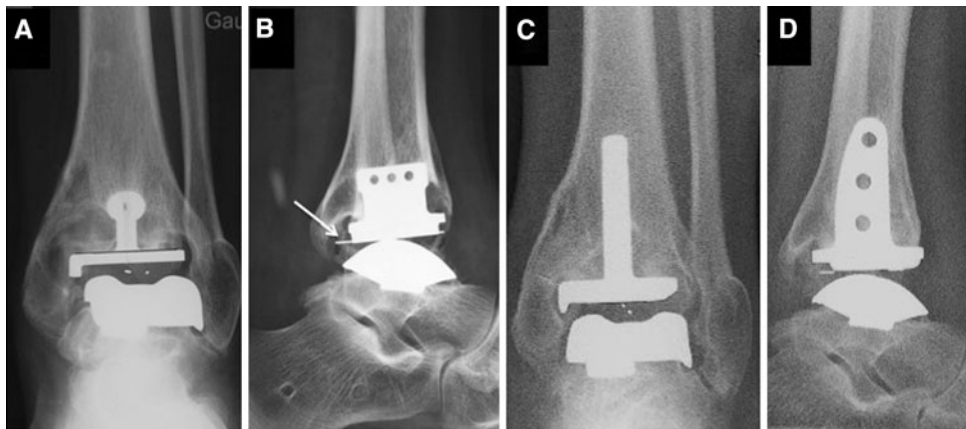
D (A) A fracture of the polyethylene occurred 8 years after implantation in the patient shown. The polyethylene was not revised until 6 months after the fracture occurred at which point concomitant revision of the tibial component was necessary as a result of the development of osteolysis. (B) On the lateral radiograph, the metal
